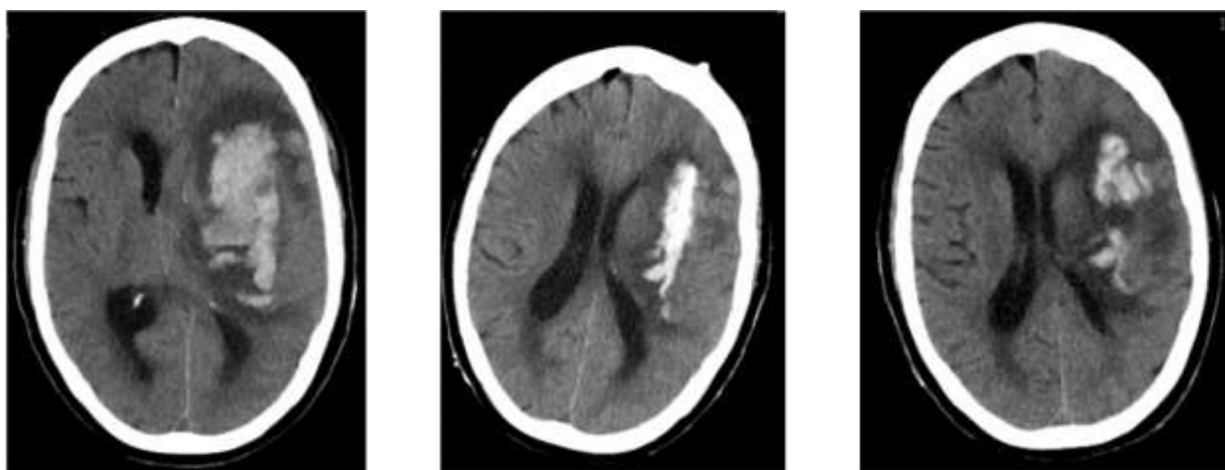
Example of poor evacuation despite good catheter placement (case #2). Axial CT scans at ICH stability (left), post-initial aspiration and catheter placement (middle) and post-thrombolytic drainage and catheter removal (right), with evidence of rebleeding after development of new coagulopathy
